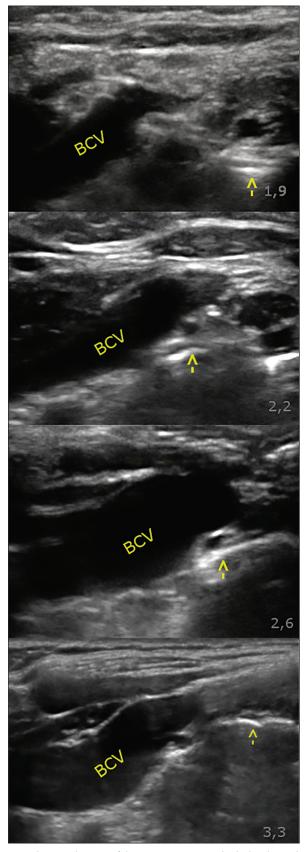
Ultrasound images of the anatomy respectively, the brachiocephalic vein of a 1 kg body weight (BW) infant, 5 kg BW, 10 kg BW child, and a 48 kg BW teen. Regardless of age and weight, always the same anatomical image can be identified. The arrows (\uparrow) mark the pleura of the lungs being visible
